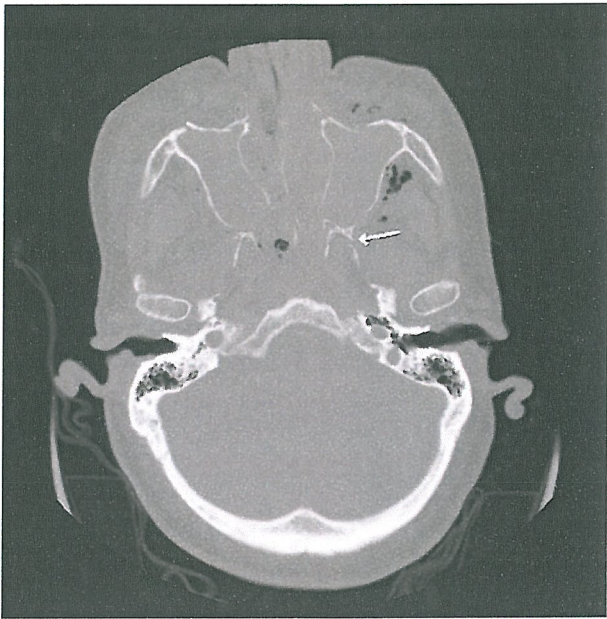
CT scan of Le Fort III fracture (arrow)
